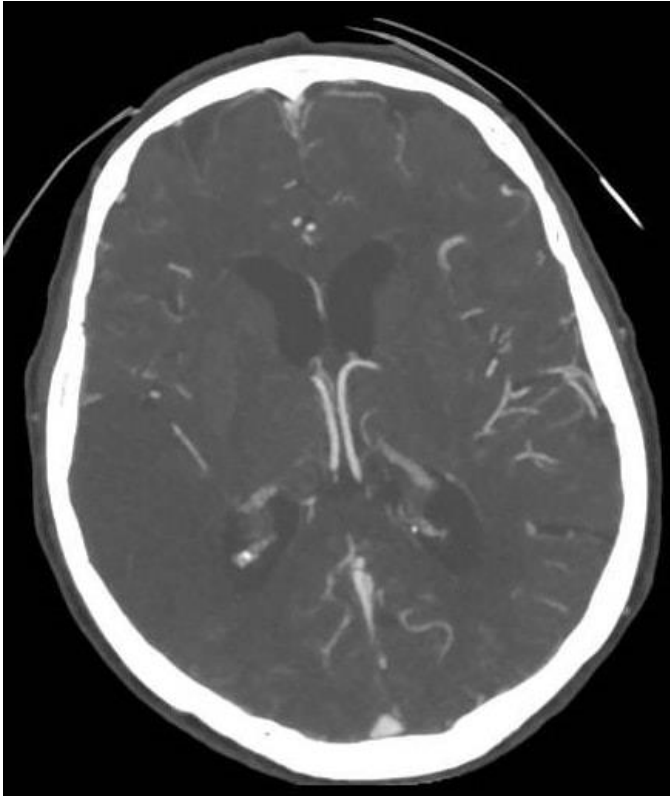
Cerebral CT angiography showing an occlusion of the temporal branch of the M2 segment of the right middle cerebral artery.
